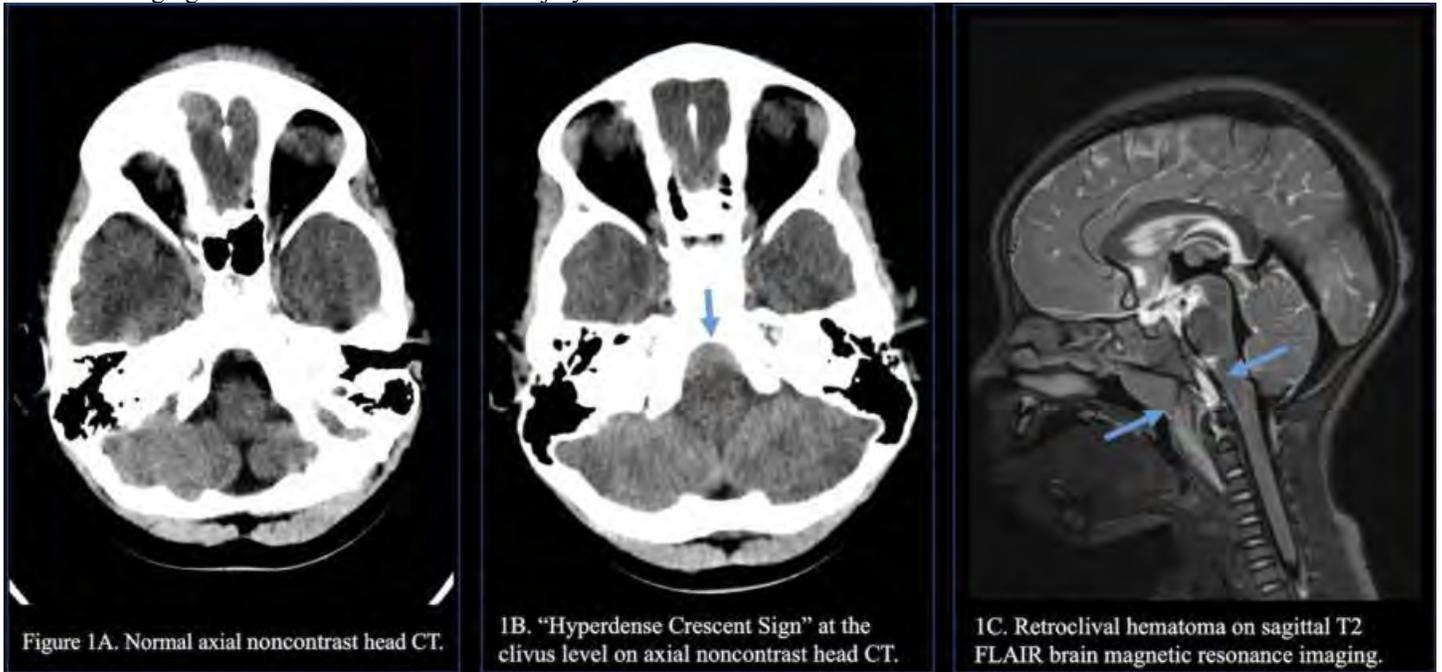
Normal axial noncontrast head CT.
